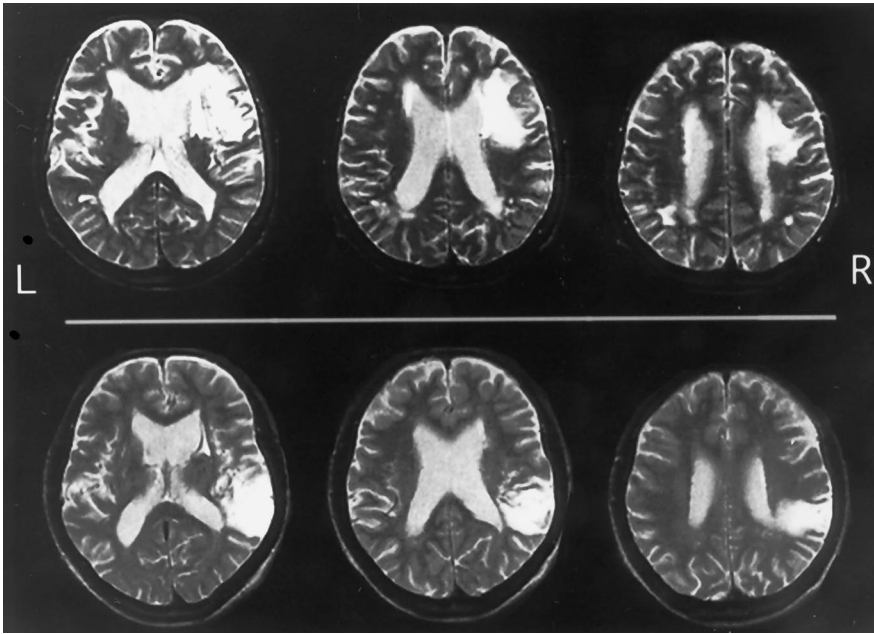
Axial T2-weighted MRI of two cases. Upper panel shows a representative case with simultanapraxia. Lower panel shows one without simultanapraxia.
